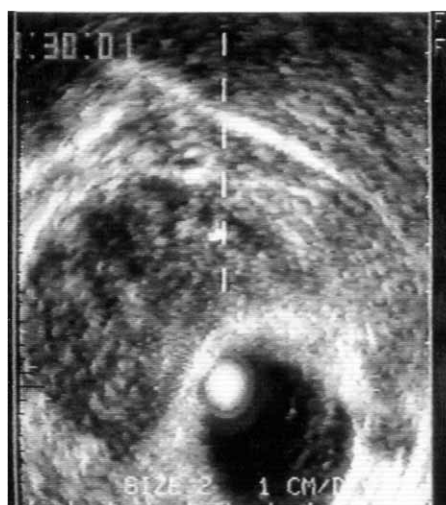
Transrectal sonography showing a false positive finding in chronic prostatitis.
